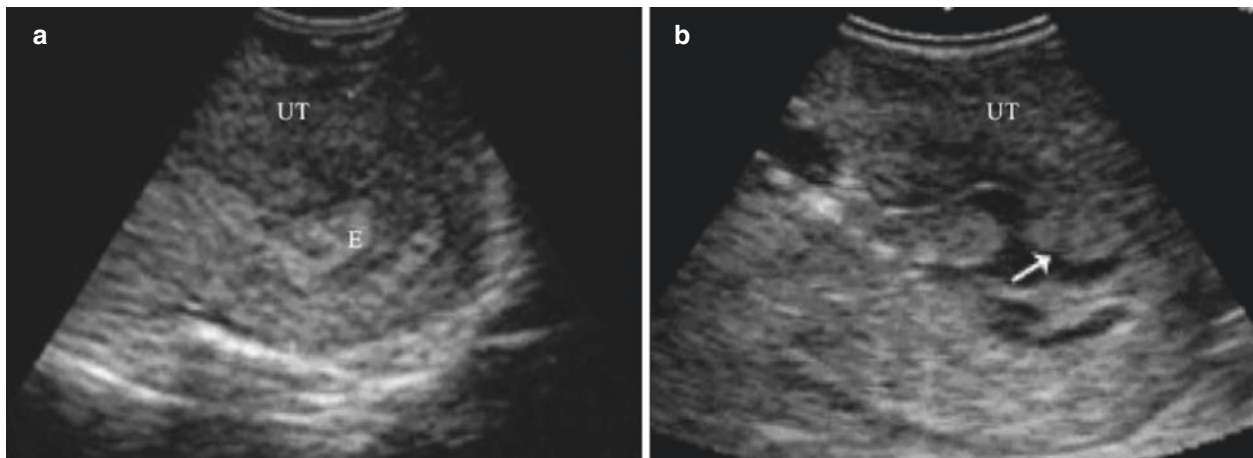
Sonohysterography of multiple endometrial polyps (I). (a) The patient is 28 years old, with history of menorrhagia and blood clot bleeding for eight months. Transvaginal ultrasound shows thickened
